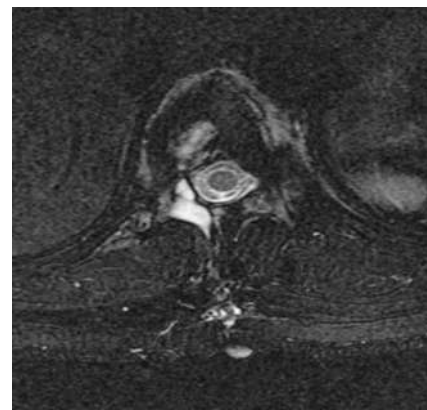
Enhanced Axial T1 MRI showing post-operative changes following biopsy and then intralaminar pedicle excision
